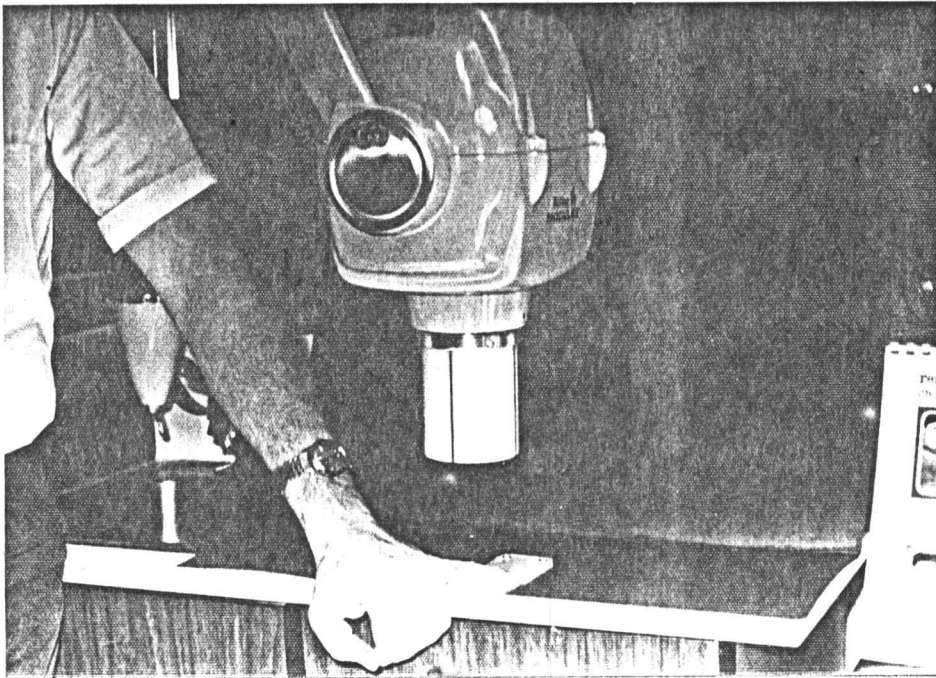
X-ray exposure.
